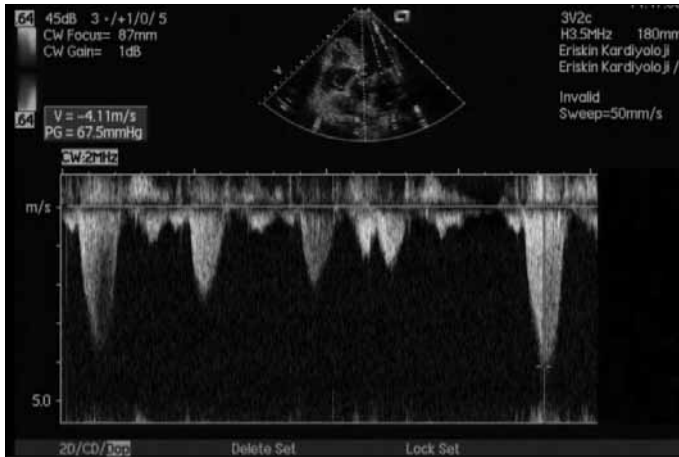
Pulsed wave Doppler velocity revealing a pressure gradient of 67.5 mmHg at rest in left ventricular outflow tract
